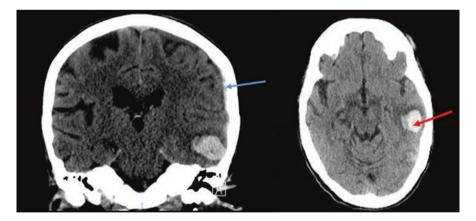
Initial computed tomography scan of head, coronal slice (left) and axial slice (right), demonstrating a left temporal subdural hematoma and parenchymal hemorrhage
